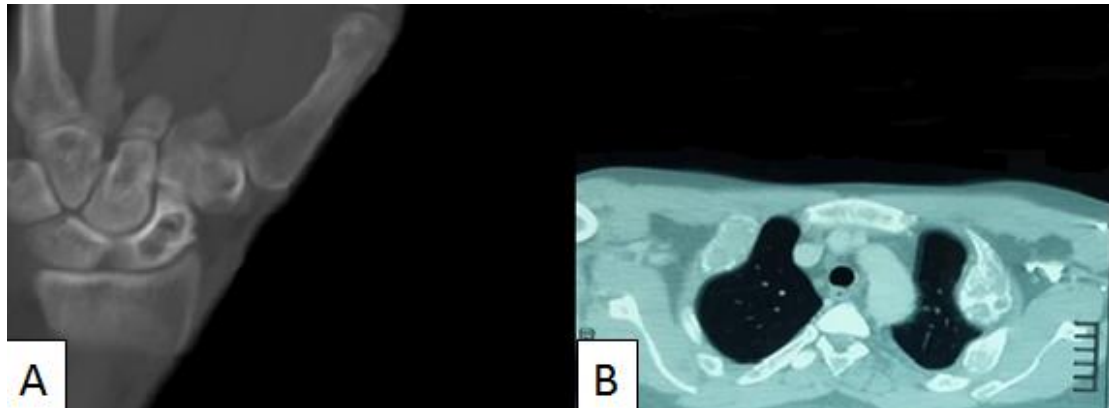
(A) CT for carpal bones showing lytic lesion in right scaphoid (black arrow). In (B); CT chest axial view showing expansile mixed solid\lytic bony lesions involving left 3rd ribs (white arrow.)
